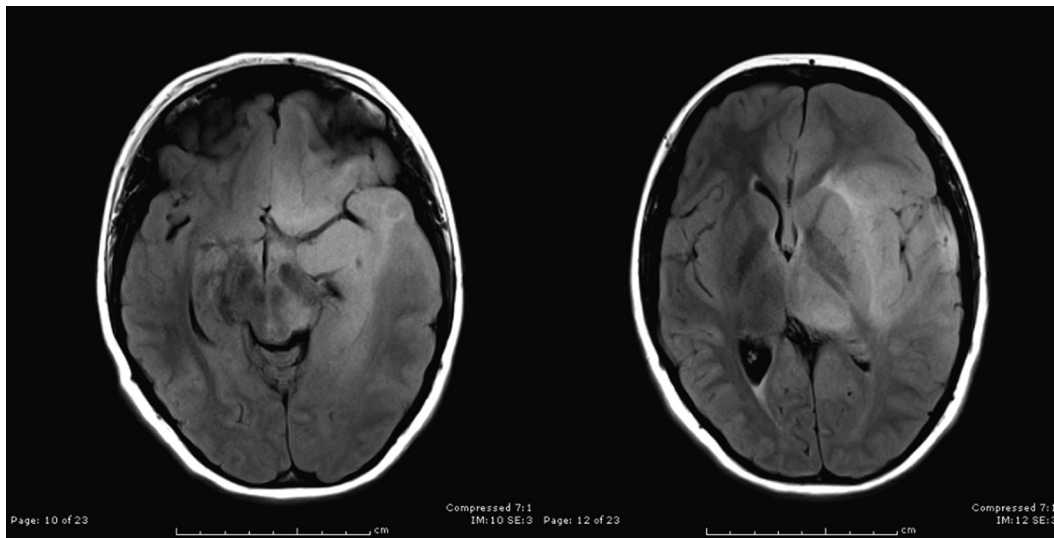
Axial fluid attenuated inversion recovery MRI of the brain (April 2012, at progression after biopsy) showing progression of left insular lesion with extension into the thalamus, frontal and temporal lobes, causing mass effect upon left ventricle, and associated midline shift.
